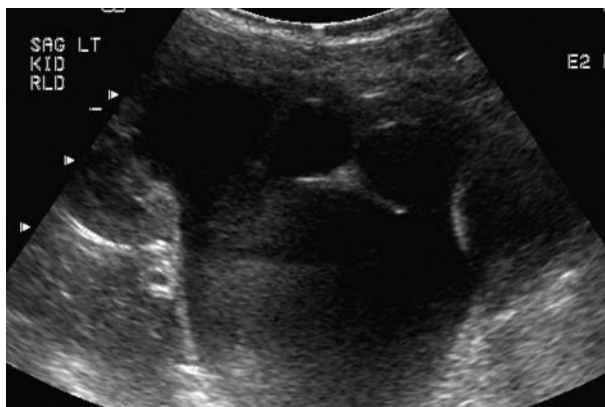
Renal ultrasound showing severe pelvicaliectasis, consistent with vesicoureteral reflux. (This patient's actual diagnosis was ureteropelvic junction obstruction.)
